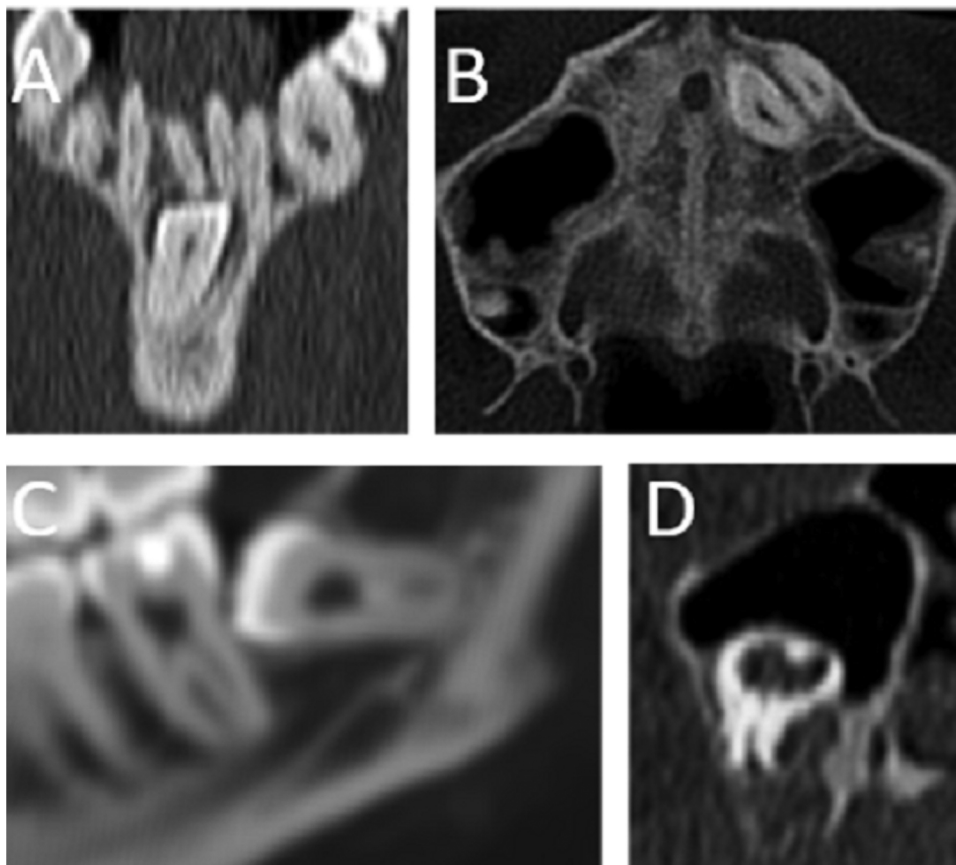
Multidetector computed tomography of the orofacial region in coronal (A and D), axial (B) and sagittal (C) planes. A) Supernumerary tooth completely enclosed in the mandibular symphysis. B) Supernumerary teeth completely enclosed in the maxillary bone. C) Unerupted, impacted third molar. D) Inverted, dysmorphic supernumerary tooth, enclosed in the maxilla, showing incipient eruption into the maxillary sinus. ©Radiology Department, Hospital Universitario de Basurto, Bilbao, Spain.
